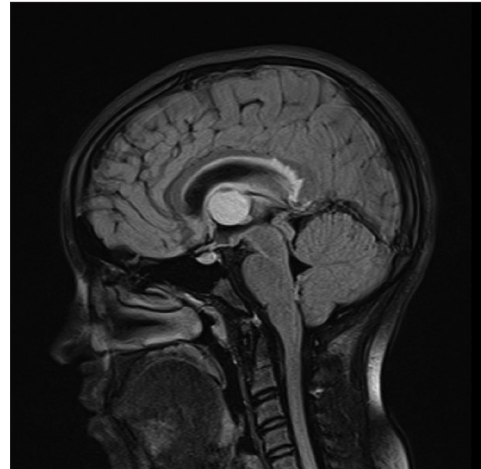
Preoperative magnetic resonance imaging of the brain showing a rounded and sharply demarcated lesion in the third ventricle.
